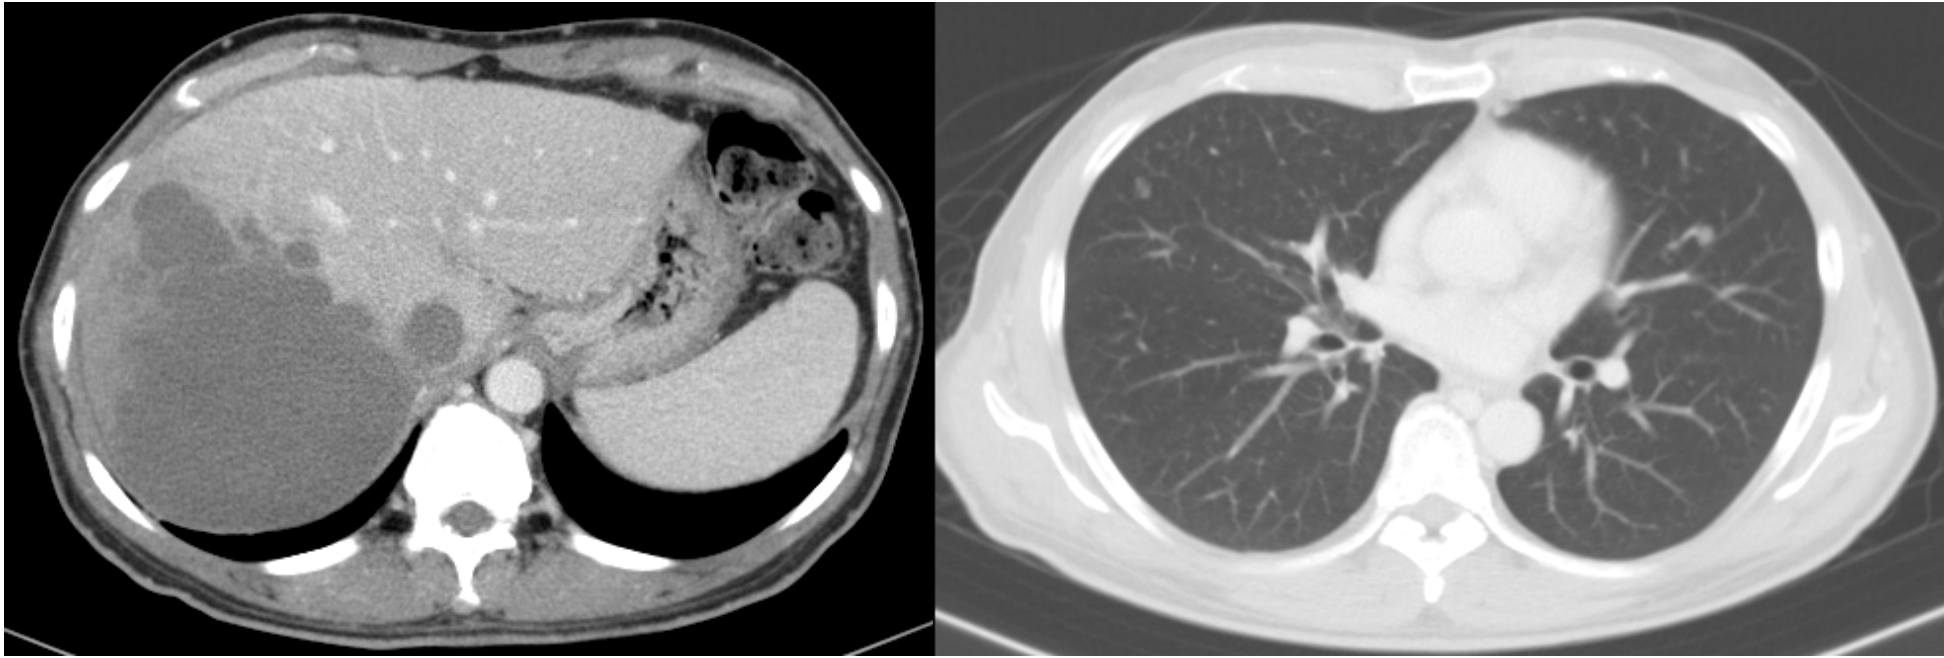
2021/12/08 CT scan : almost cystic change of HCC and lung mets.
